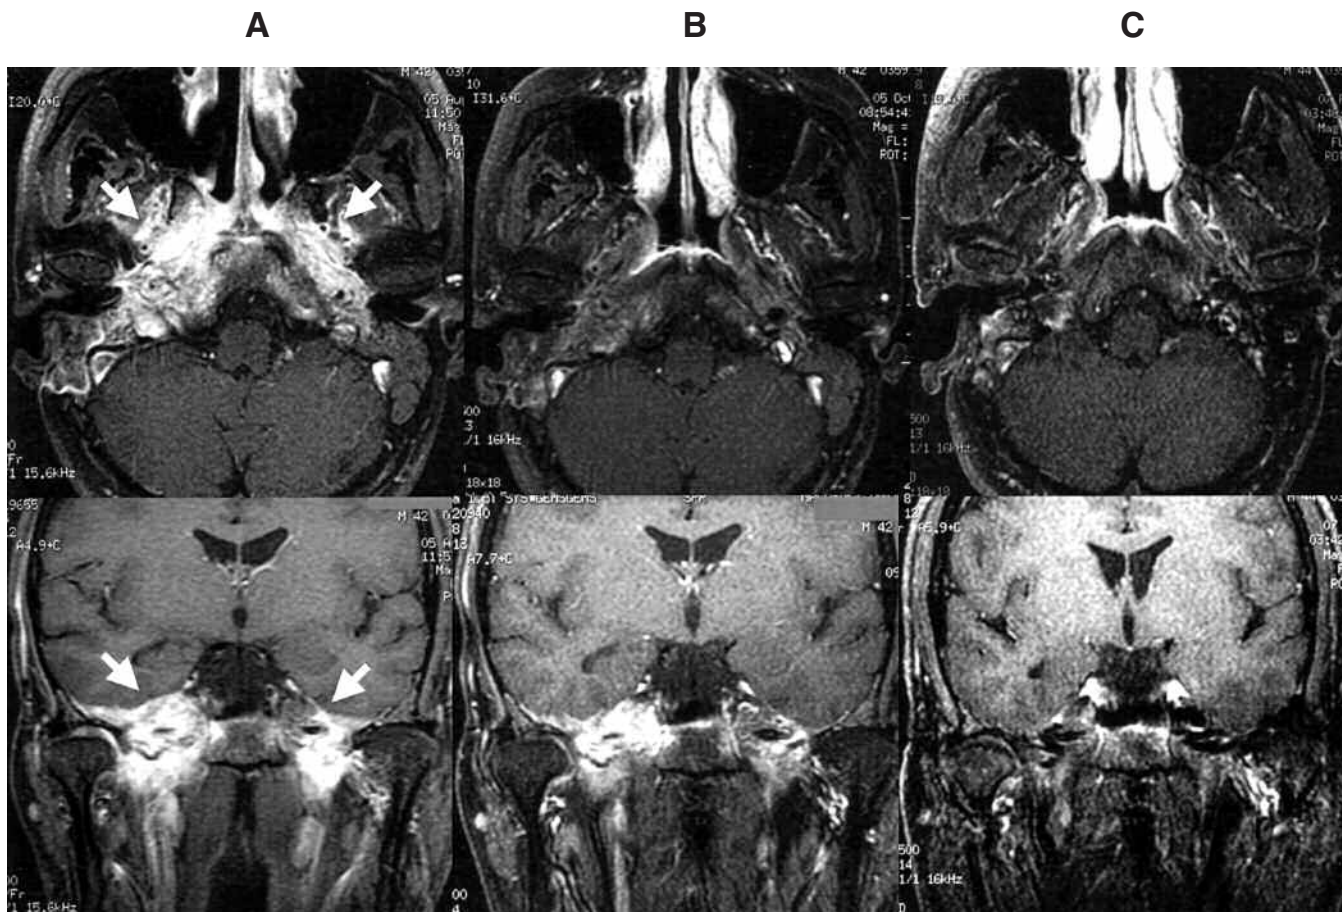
Axial and coronal T1-weighted MR images with gadolinium enhancement before infliximab injection (A) and after infliximab injection at Weeks 14 (B) and 80 (C). Abnormal MRI features were unresolved by conventional therapy (A). However, the area was reduced by infliximab therapy (B and C).
